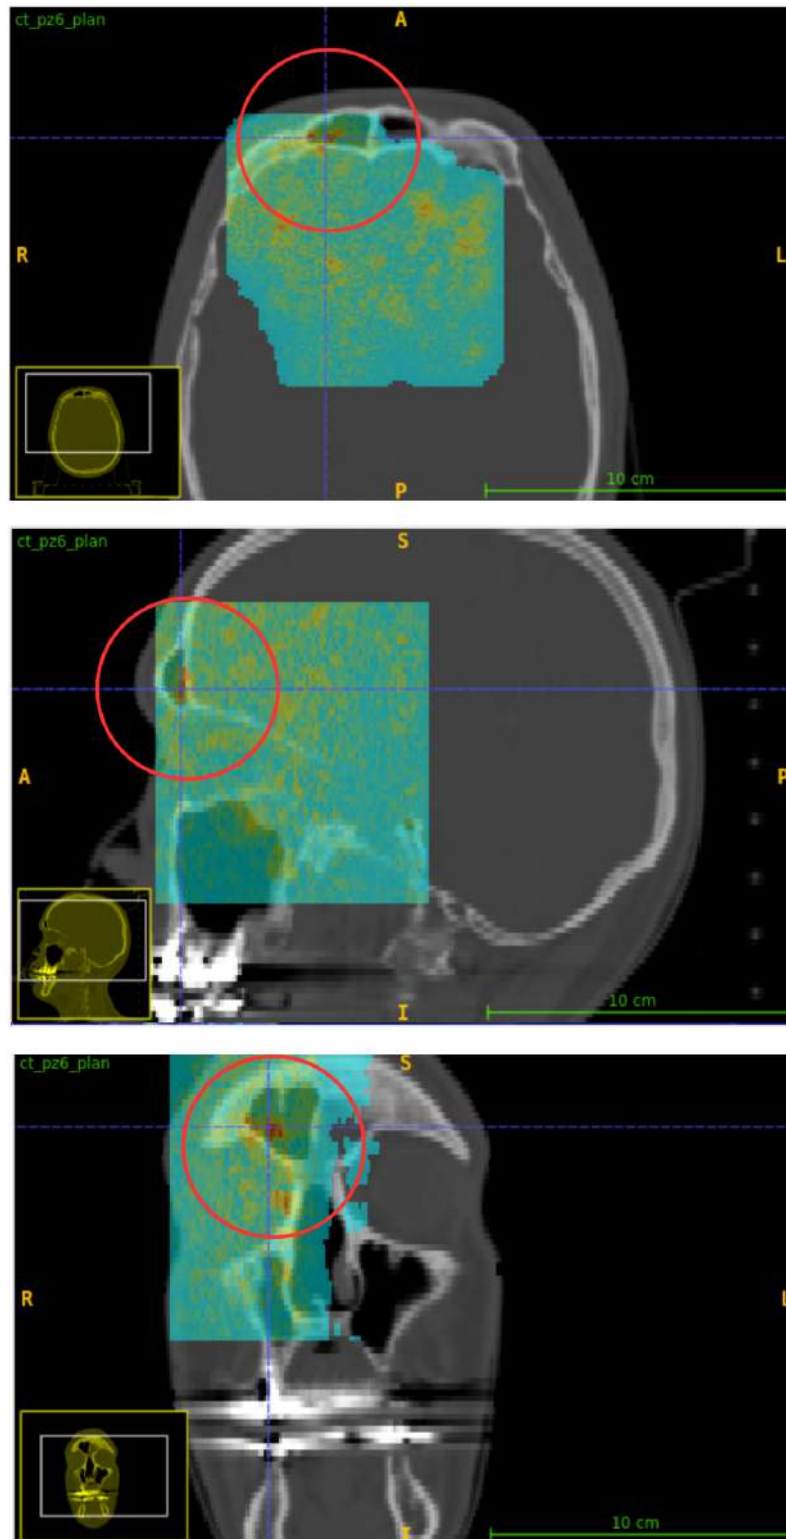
Gamma mode map for  $DD = 1.5\%$ ,  $DTA = 20\text{ mm}$ ,  $DTH = 0\%$  in axial, sagittal and coronal views (from top to bottom), overlaid on the planning CT. Only the small morphological variation is detected (red circle), whereas the larger morphological change is not identified.
